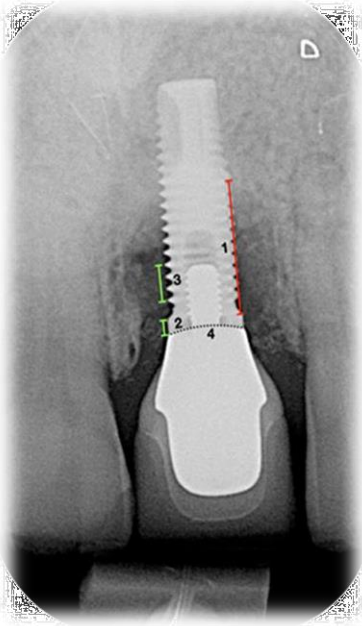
Typical radiographic and clinical appearance of advanced peri-implantitis.(Klinge *et al.*, 2018; Sahrman *et al.*, 2024)
